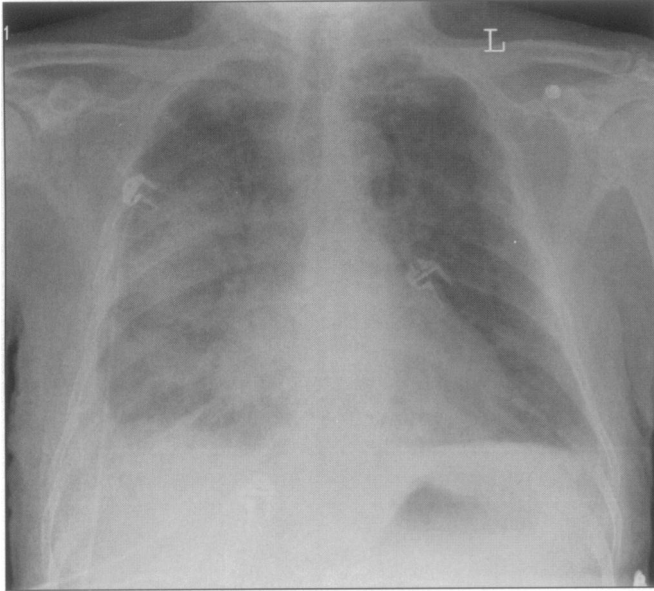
X-ray of patient 2, showing pronounced venous redistribution and pleural fluid compatible with pulmonary oedema.
